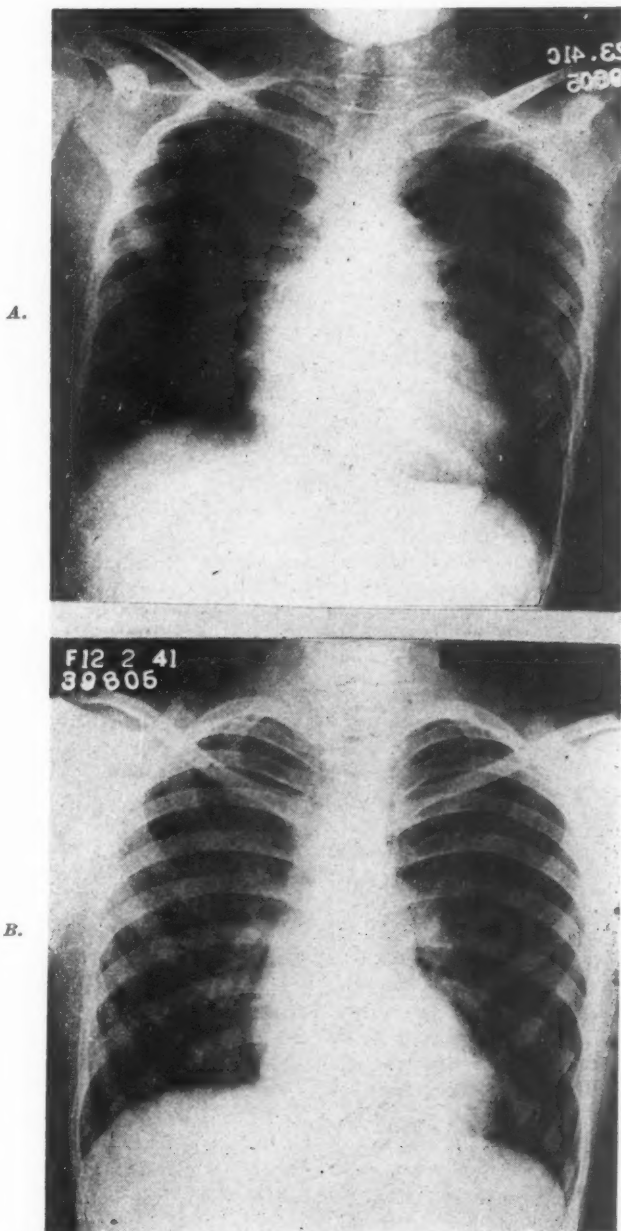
Roentgenograms in Case 1. *A*, which is not a teleroentgenogram, was made July 23, 1941. *B* is a teleroentgenogram made Dec. 2, 1941. Each film demonstrates slight cardiac enlargement and prominence of the pulmonary artery. There is also a partial left pneumothorax present in the lower film. Because of the prominent pulmonary artery, the diagnosis of Eisenmenger's complex was made.
